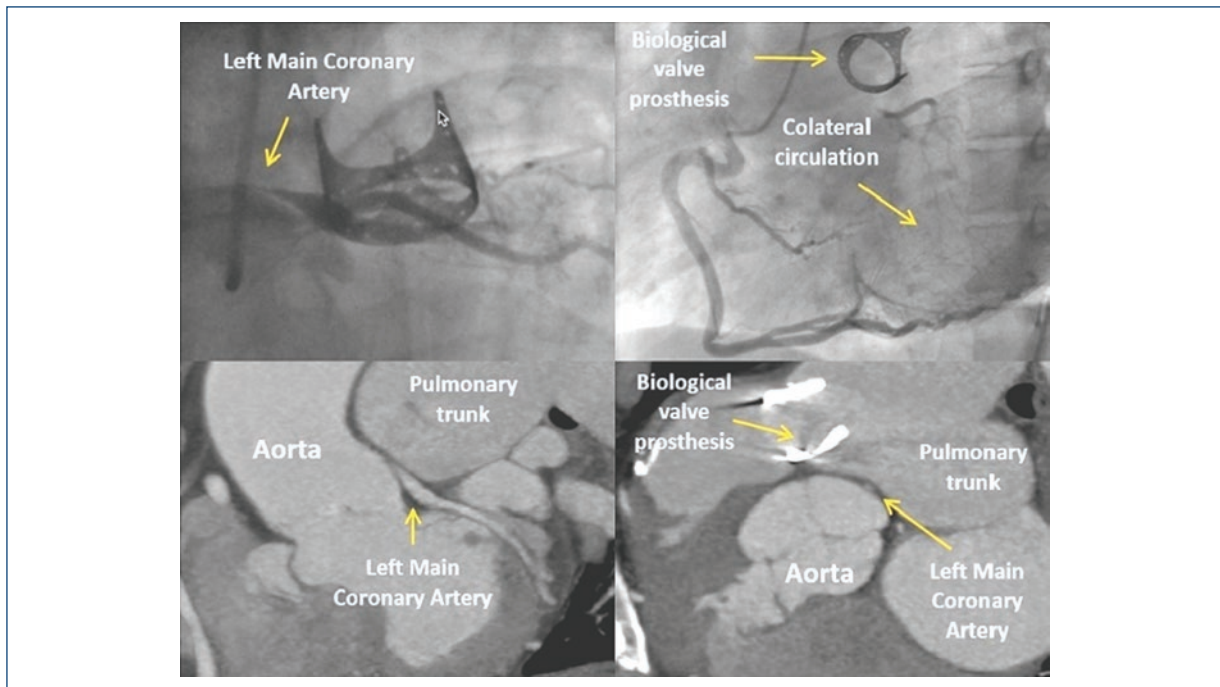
Extrinsic left main coronary artery (LMCA) compression of 90% and reduced blood flow to the left anterior descending with collateral circulation from de RCA in coronary angiography. LMCA compression by the pulmonary artery in computed tomography.
